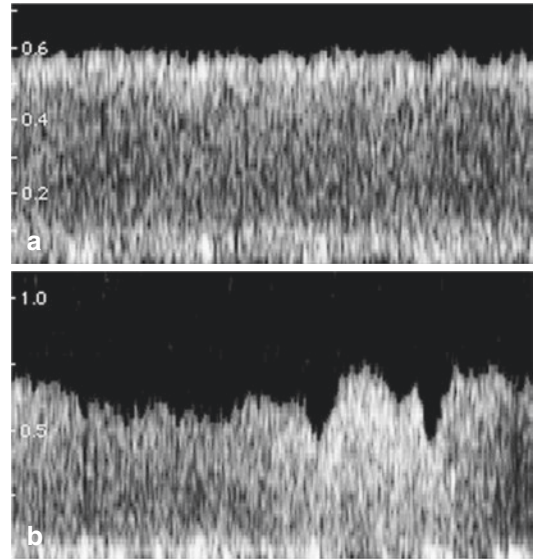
Doppler recording of the ductus venosus blood velocity without pulsation (upper panel) due to the fetal position bending forward and squeezing the ductus venosus outlet. The wave has been completely reflected at the junction with the inferior vena cava (see Fig. 5.13b). Seconds later, a change in fetal position restores the dimension of the vessel (corresponds to Fig. 5.13a) and the pulsatile flow pattern (lower panel). (Modified from [48])
